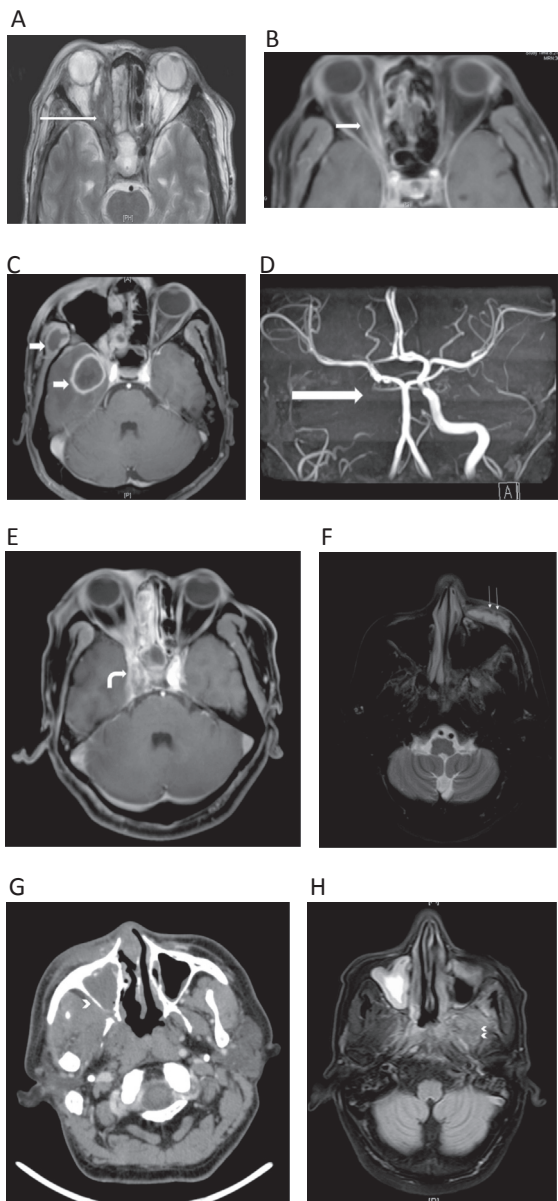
Involvement of regional structures A. Ill defined iso to hypointense soft tissue in the orbit (long thin arrow) B. Thickening and peripheral enhancement of the right optic nerve (short thin arrow) C. Abscess involving the right temporal lobe and right temporalis muscle (short thick arrow) D. Non visualisation of the right internal carotid artery, suggestive of thrombosis (long thick arrow). E. Non enhancing soft tissue in the right cavernous sinus, suggestive of thrombosis (curved arrow). F. Abscess formation involving the left premaxillary region (double arrow) G. CT showing soft tissue opacification of the right maxillary sinus with involvement of retromaxillary fat (arrowhead) H. ill defined hyperintensity involving the left masticator space and pterygopalatine fossa (double arrowhead).
